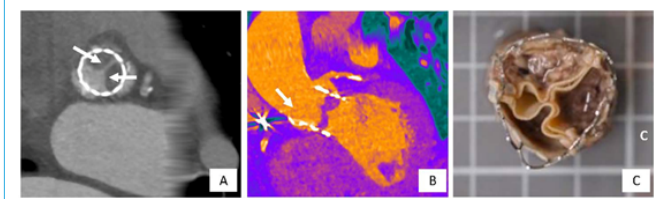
Computed tomography imaging and macroscopic appearances of Edwards Sapien Ultra thrombosed leaflets: Panel A: Multidetector computed tomography in transversal axis shows hypoattenuated mass near the stent frame (arrows) that extend to the cusp with decreased leaflet movement, confirmed in long axis by Panel B. Panel C: Explanted transcatheter heart valve demonstrating thrombosis.
